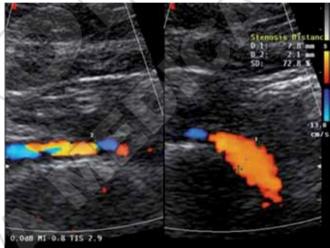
Abdominal transparietal duplex ultrasound. Compression of common left iliac vein (May–Thurner Syndrome) note the decrease of the flow at left primitive iliac vein level.
